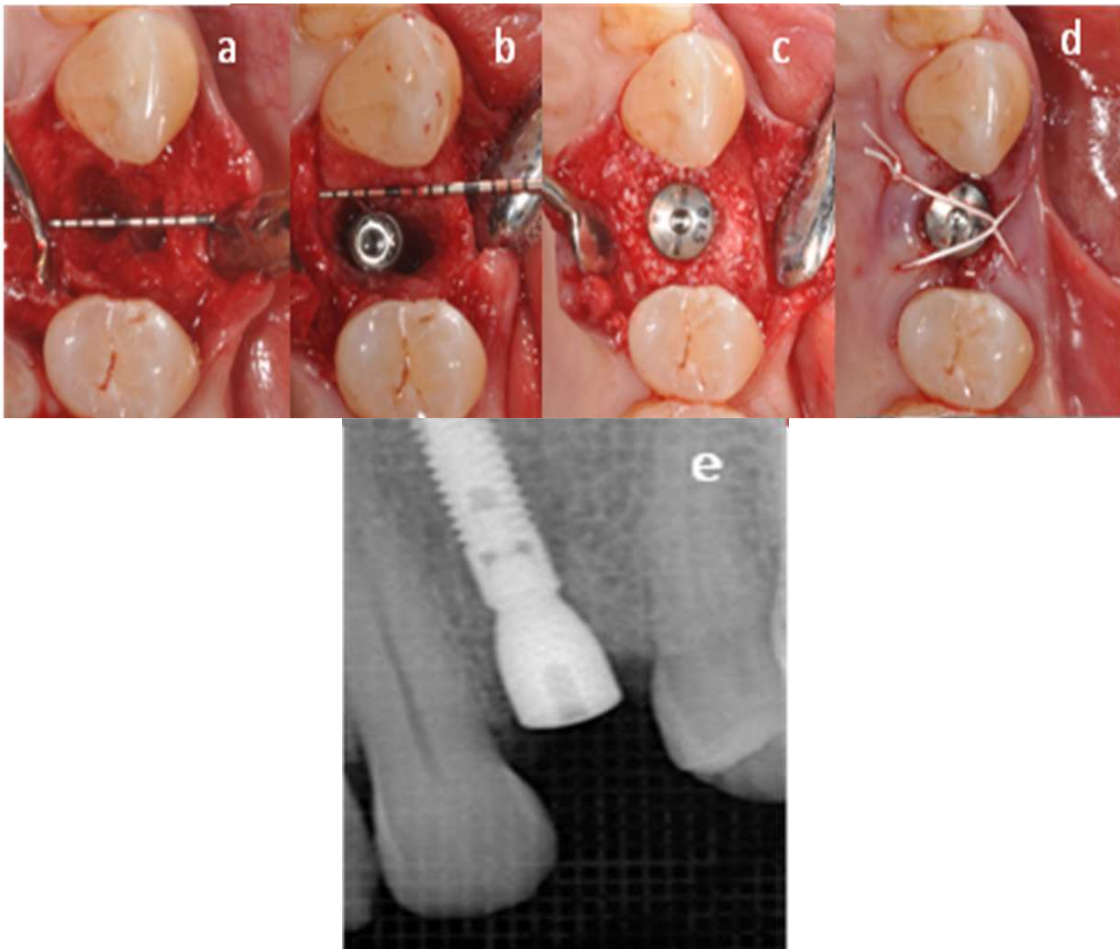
Implant surgery. (A) Fresh extraction socket. The apical part of the interradicular septum is remove to facilitate implant insertion. (B) Correct 3D positioning of the implant. Note the gap between cortical bone walls and the implant surface. (C) The gap is filled with xenograft and a transmucosal healing abutment is placed. (D) The flaps sutured against the healing abutment with e-PTFE suture. (E) Periapical radiographic after implant placement
